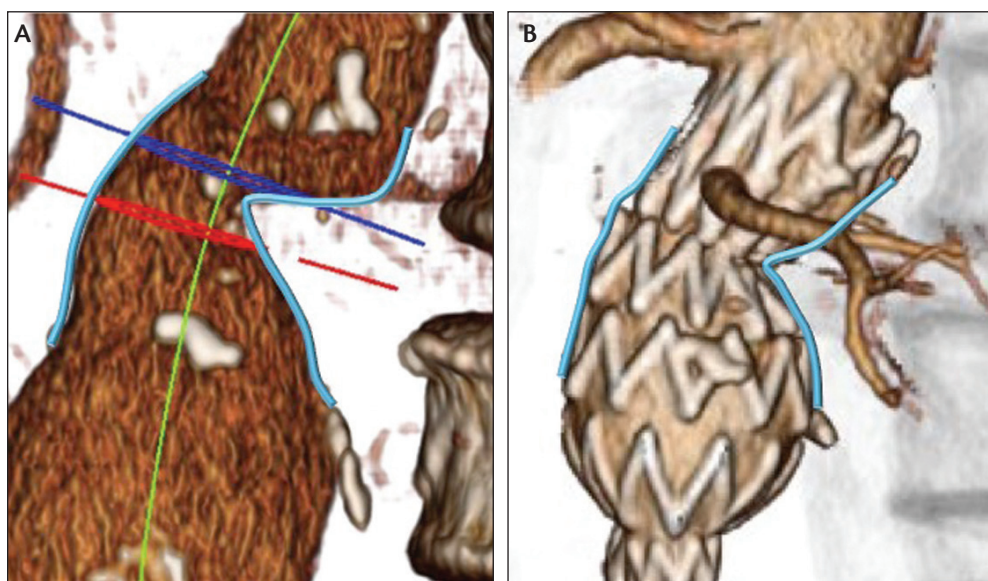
Preoperative CT angiogram of an AAA with an hourglass configuration of the proximal aortic neck (A); postoperative CT angiogram showing the excellent conformability of the INCRAFT® Stent Graft System to the native aorta anatomy (B).
